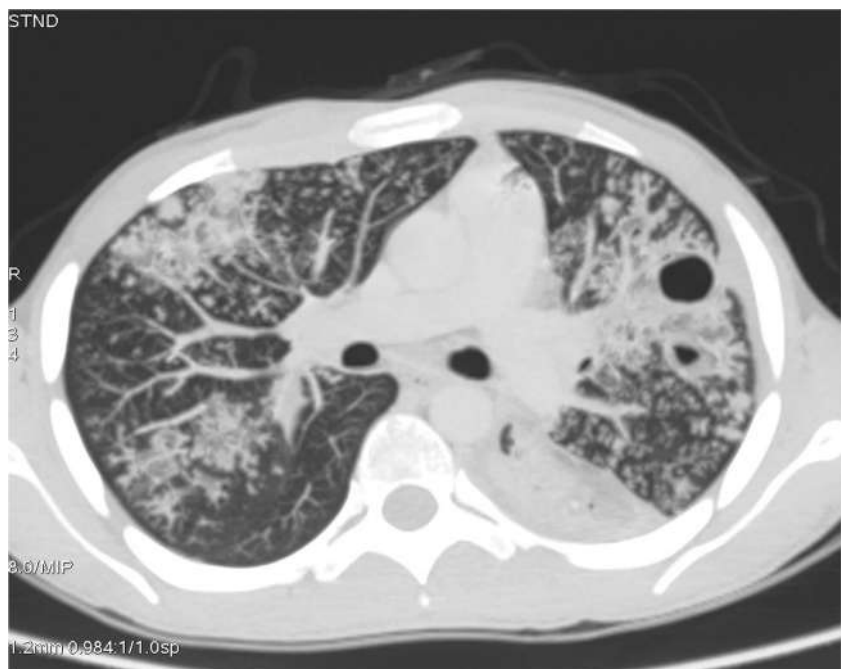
Endobronchial spread: axial section of the thorax in a 60-year-old female diabetic with smear-positive tuberculosis with normal X-ray chest. Multiple tiny tree-in-bud lesions are seen in the lower lobe of both lungs
